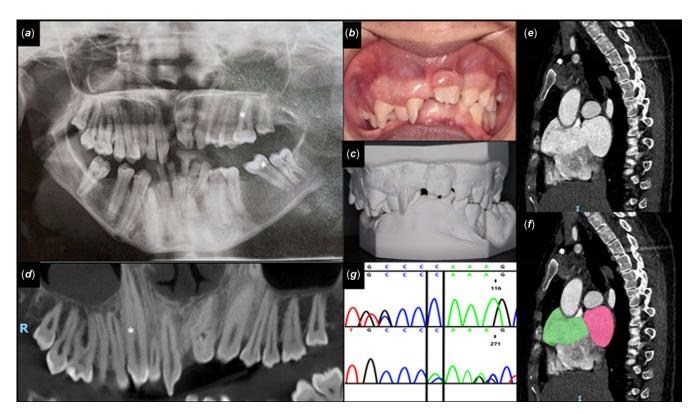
Radiological (*a*), clinical (*b*), 3D scanner reconstruction (*c*), and cone-beam computed tomography (*d*) dental findings: radiculomegaly are marked (white *). Cardiac scan sagittal view showing the large atrial septal defect (*e*) with dilated right atrium in green and left atrium in red (*f*). Electropherogram of GrCh37: NM_01123385.1(*BCOR*): c.2093delC; p.(Pro698Glnfs*17) (*g*).
